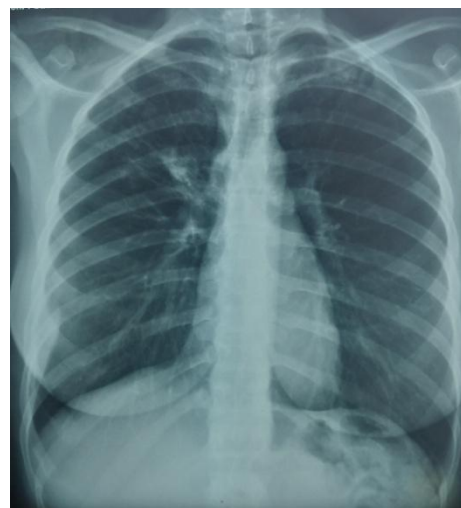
Radiography of the thorax face: opacity under the right axillary + bilateral upper nodular opacities
